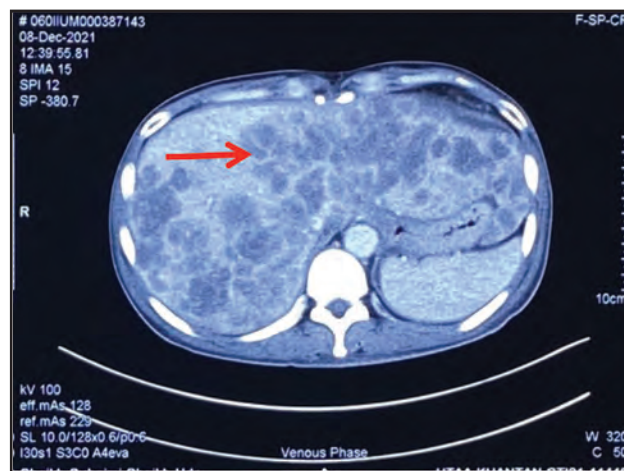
CT TAP showing extensive (arrow) liver metastases.
